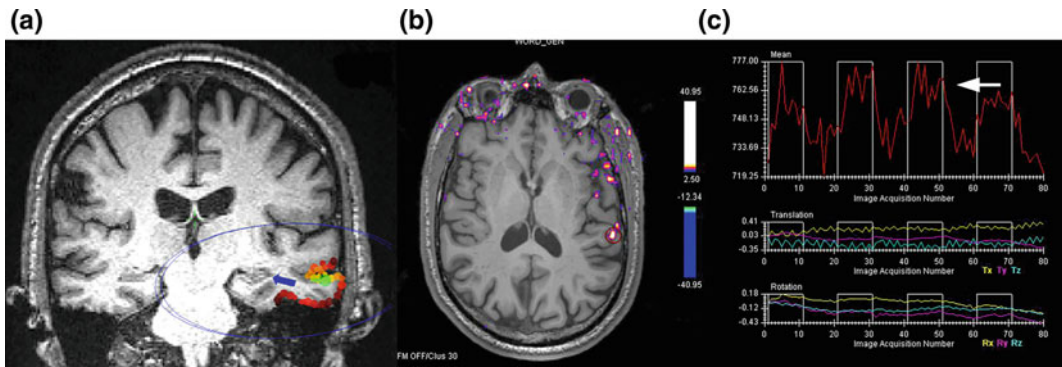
Advanced imaging workup in patient with MRI-negative left temporal lobe epilepsy. Coronal MPRAGE with interictal MEG dipole cluster in the left middle temporal gyrus (*blue arrow*, panel a) was concordant with semiology and EEG. Task-based
